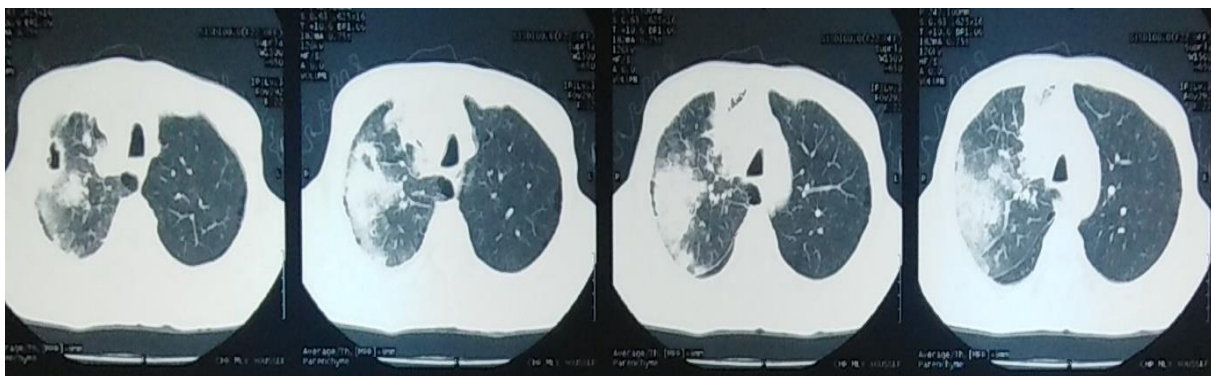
Axial chest computed tomography findings in a 55-year-old male with adenocarcinoma of the right lung also infected with COVID-19.
